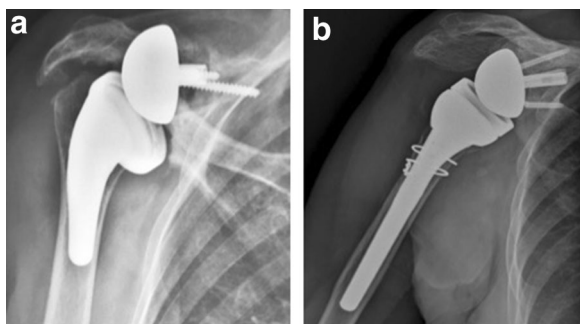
Aseptic loosening of glenoid component in RSA. a Post-traumatic loosening of glenoid component 9 months after shoulder reverse arthroplasty surgery. b X-ray 1 year after the replacement of both glenoid and humeral components of the RSA with revision implant
